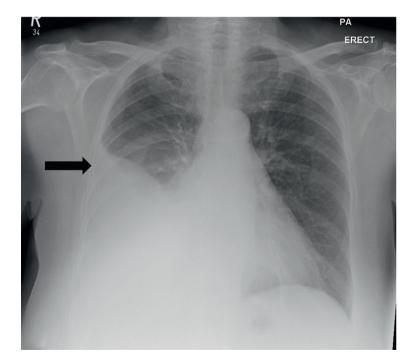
Chest X-ray showed the presence of right-sided pleural effusion.
